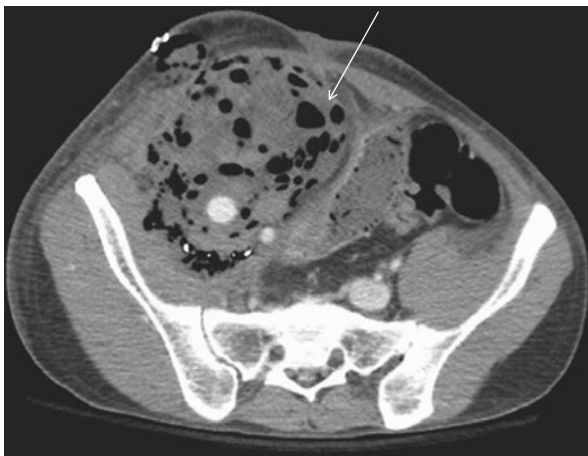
A CT image of a complex intra-abdominal fluid collection with free air (*arrow*) and fecal contamination requiring surgical exploration
